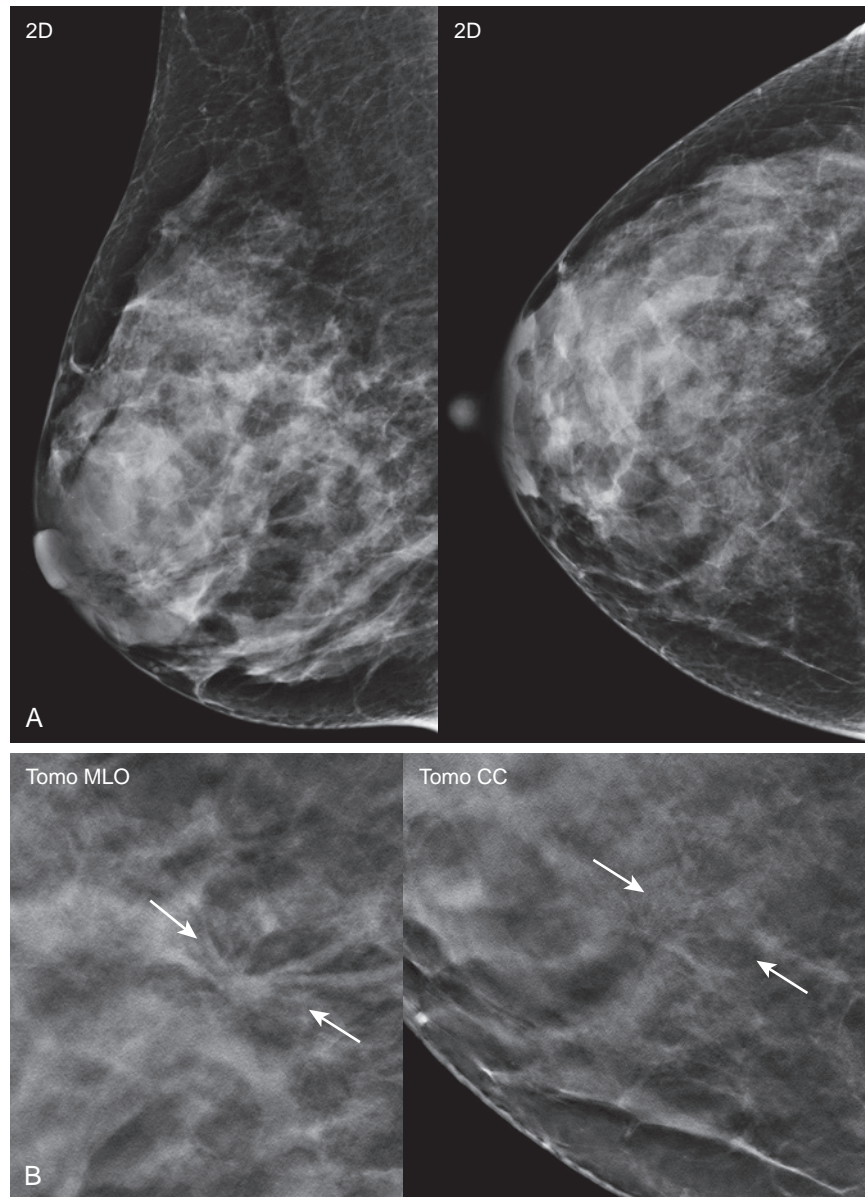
Wire localization. A 44-year-old woman with family history of breast cancer presents for annual screening mammography. (A) 2D MLO and CC views show heterogeneously dense breast tissue with no suspicious findings. (B) Tomosynthesis reveals focal architectural distortion in the superior medial breast (*arrows*), best seen in the MLO projection. Ultrasound was negative (not shown).
